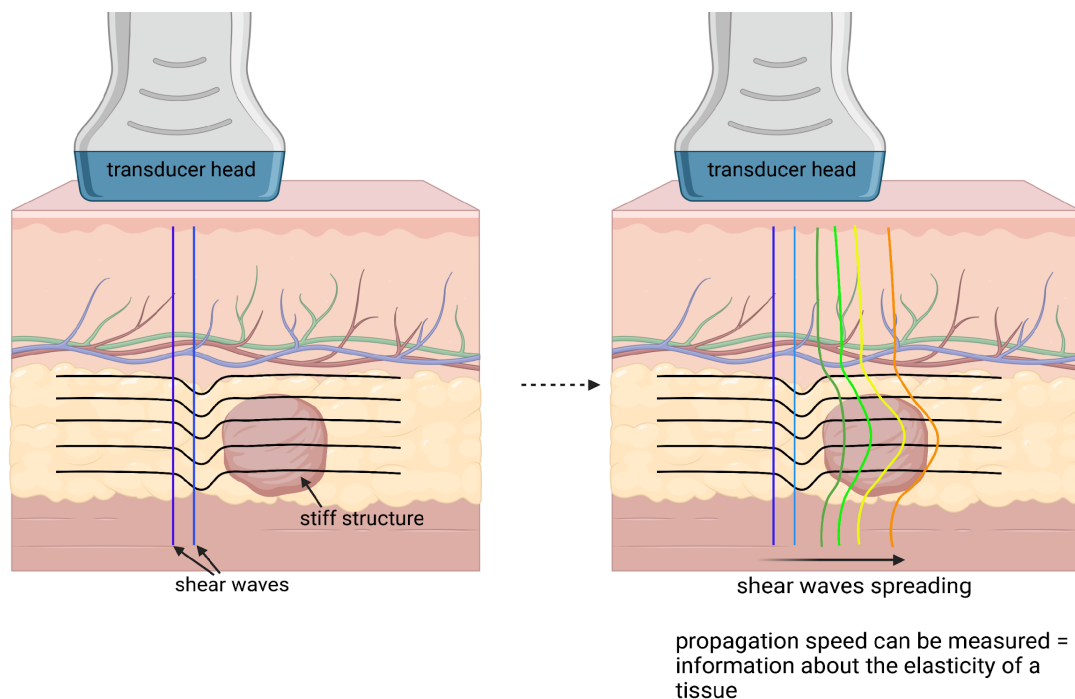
Shear waves travelling through a stiff structure in body tissue. (Own representation) The ultrasound transducer head emits the shear waves which transverse through the body tissue. (In this representation the shear waves are travelling from left to right). Once the shear waves reach the stiff structure the shear waves alter their propagation speed which can be measured and then used to calculate the elasticity of the stiff structure.
